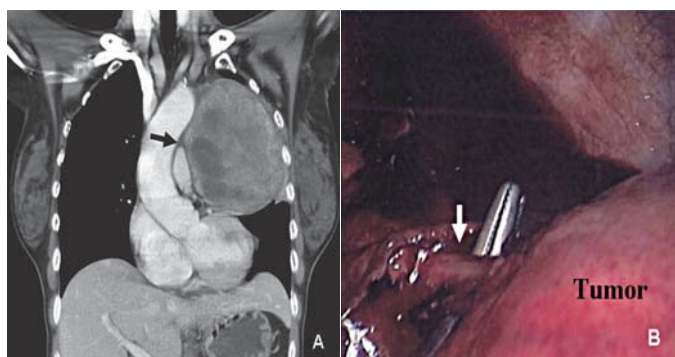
65 year-old female with a large mediastinal schwannoma. A. Coronal CT with contrast shows a circumscribed heterogeneous mass measuring about 11x11x8.5 cm with soft tissue and cystic components (arrow). B. Intraoperative view shows that the tumor derived from the left vagus nerve (arrow).
